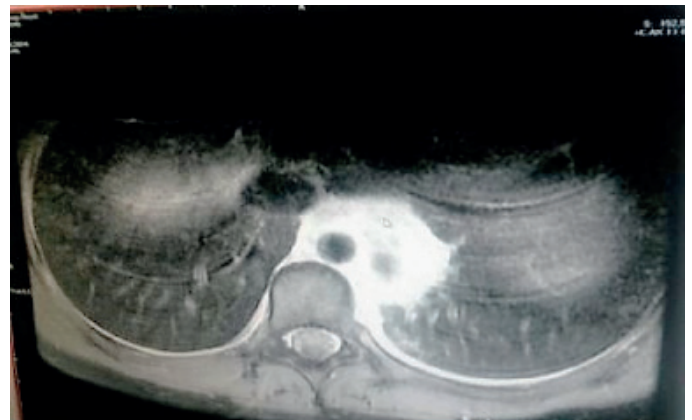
High signal areas associated with edema and inflammation with T2 images of mediastinal magnetic resonance imaging on mediastinum subcarinal area from thoracoabdominal junction towards the left paraaortic field (before the treatment)
